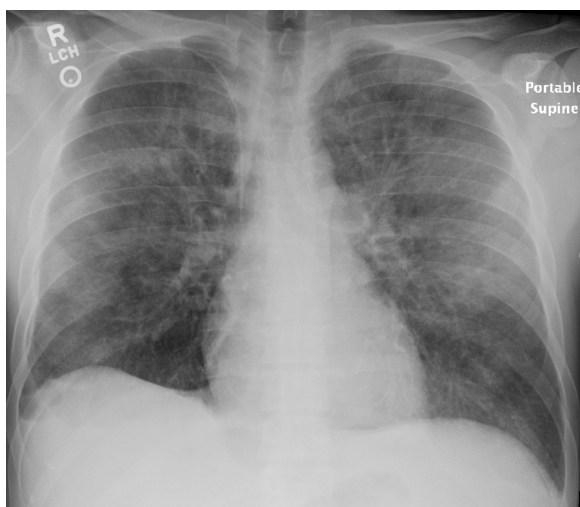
Chest x-ray at admission.
